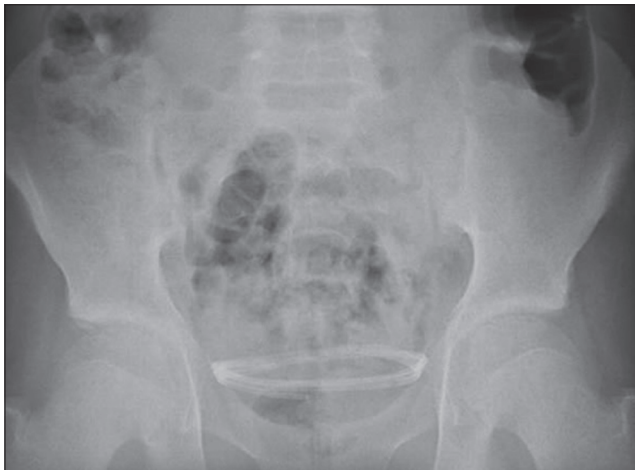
Control abdominal X-ray showing that the shunt material completely migrated into the pelvic inlet
